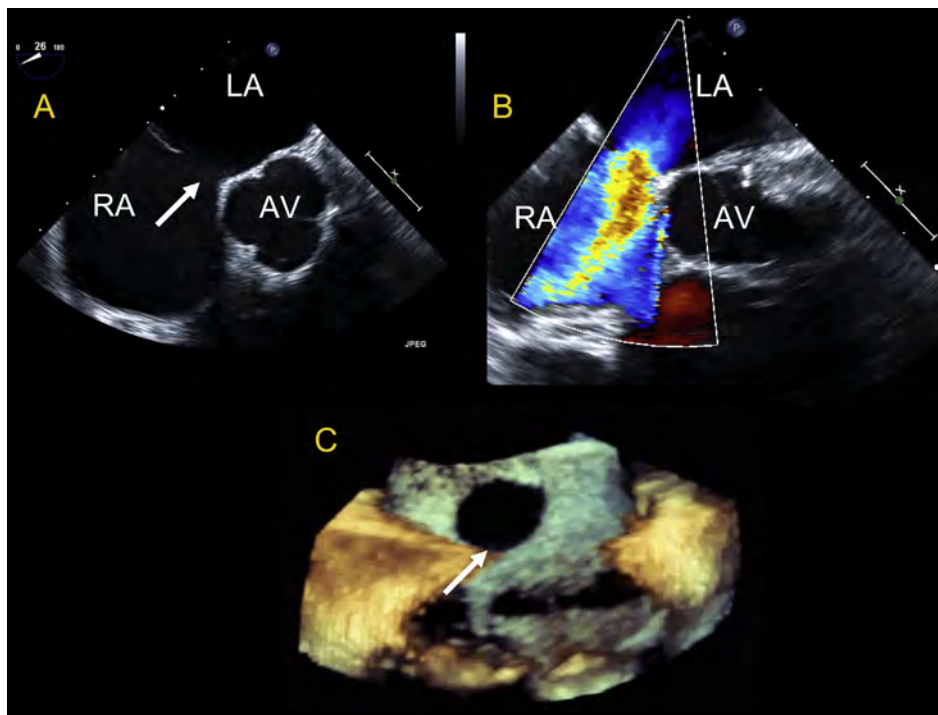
Three-dimensional TEE of medium size ostium secundum ASD with a mildly deficient aortic rim. (A) Midesophageal aortic valve short-axis view demonstrating ASD and aortic rim deficiency. (B) Similar view demonstrating brisk left to right color Doppler flow. (C) Zoom acquisition of ASD en face from RA perspective. White arrow indicates ASD. AV, aortic valve.
